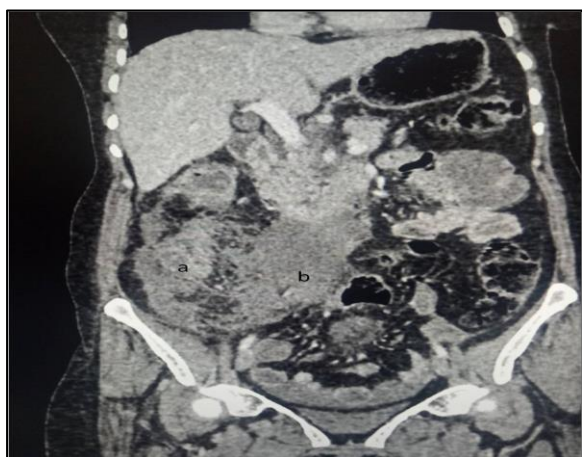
Emergency CT scan showing a stenosing thickening of the right colon (a) with a mesenteric hemorrhage (b) of a patient with COVID-19.
